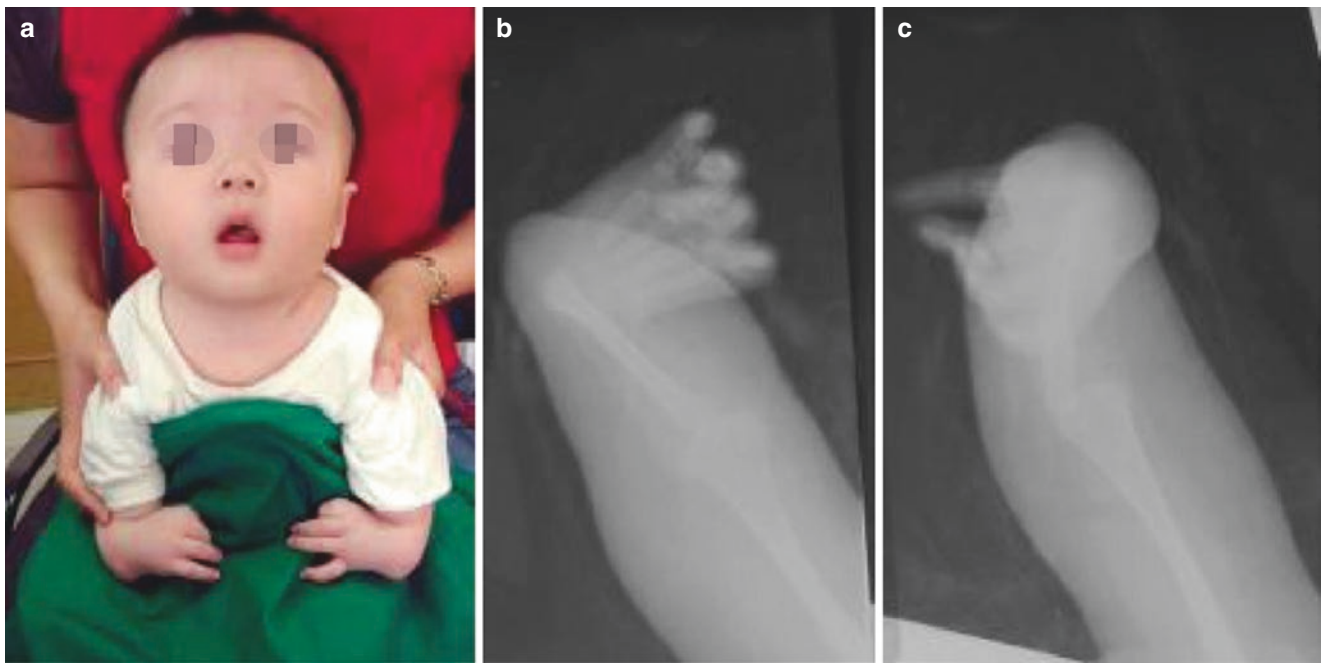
Bilateral radial club hands. (a) Hand appearance. (b, c) X-ray findings
